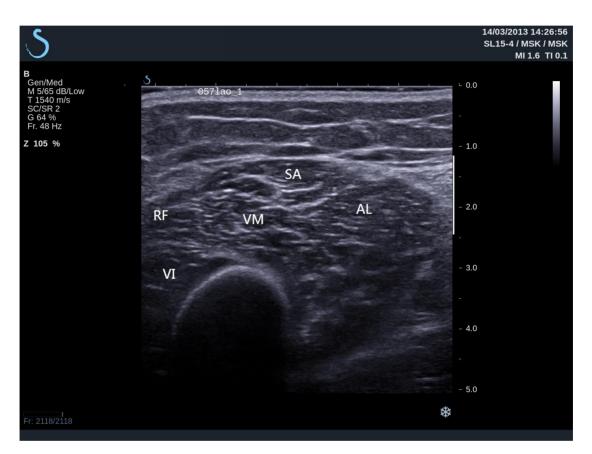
Ultrasound image of 1/3 of the leg length above the base of patella. The length is from anterior superior iliac spine (ASIS) to the medial side of joint line space. RF: Rectus femoris; VI: Vastus intermedius; SA: Sartorius; VM: Vastus medialis; AL: Adductor longus.
